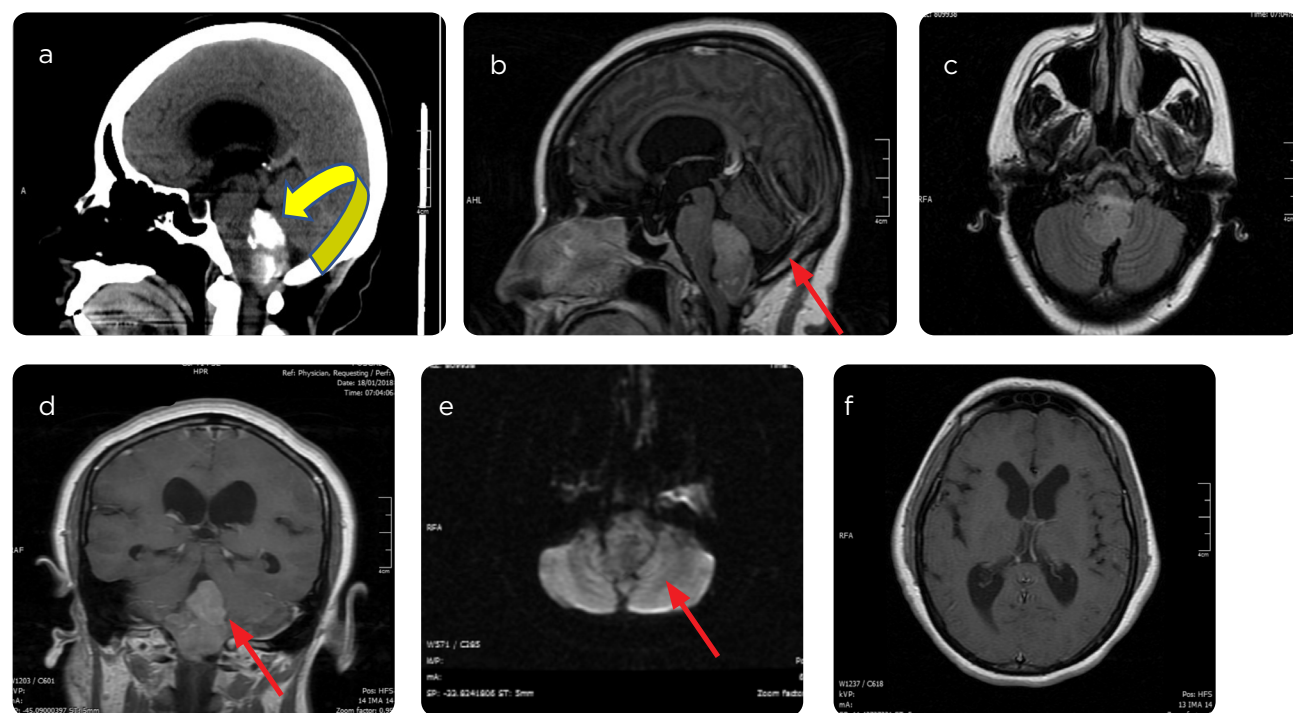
Carcinoma of the choroid plexus of the IV ventricle. a) CT scan: heterogeneous density with areas isodense to the parenchyma and calcifications. b) MRI with T1 information: isointense to the brain parenchyma. c) Sequences with T2 information of intermediate to high signal. d) With contrast medium: enhancement. e) Diffusion sequence: no restriction to water diffusion. f) Supratentorial axial image: dilatation of the ventricular system.
